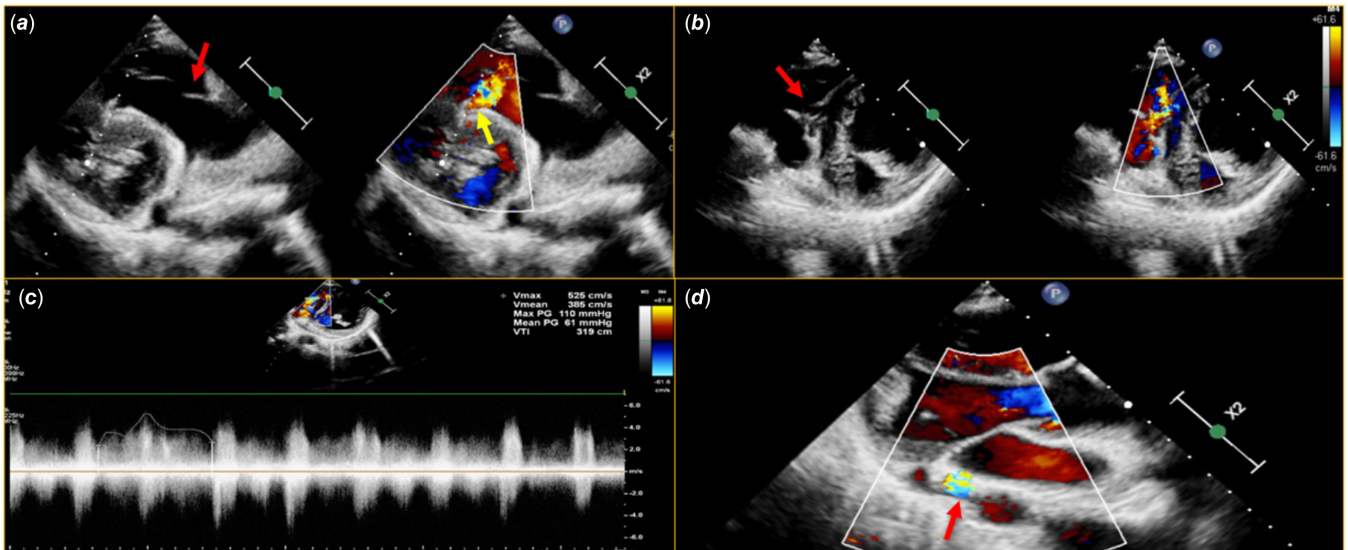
a.* Modified parasternal long-axis view showing a red jet into right ventricle (yellow arrow), note that flow is in diastole while tricuspid valve is open (red arrow); *b.* Parasternal short axis view showing similar red jet with defect in the inter-ventricular septum (arrow), mimicking a ventricular septal defect; *c.* Gradient across the defect was 110/61mmHg, note the continuous flow; *d.* Parasternal long-axis view showing dilated left circumflex artery in left atrioventricular groove (arrow).
